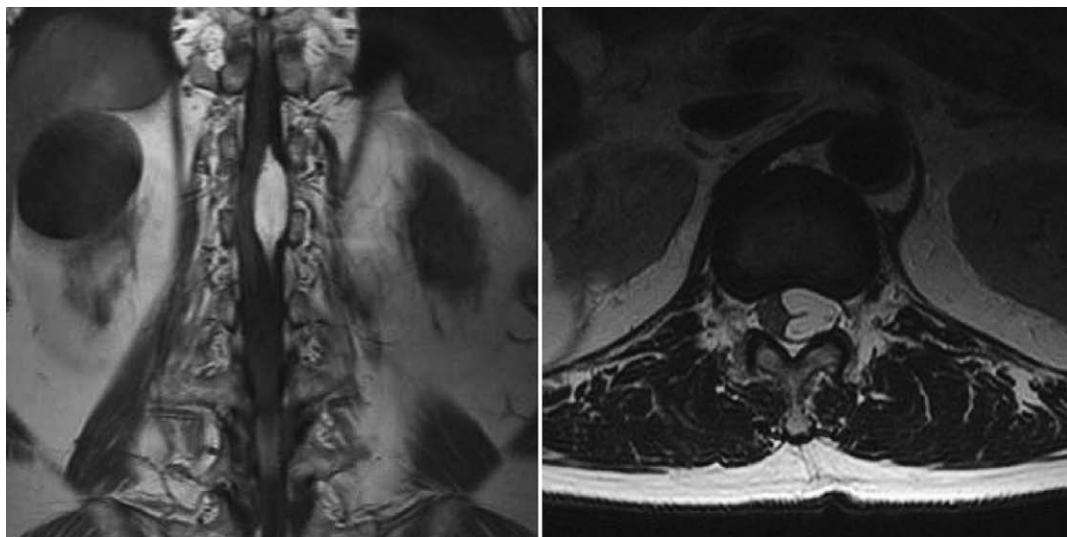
Preoperative MRI. Coronal T1-weighted and axial T2-weighted images.
